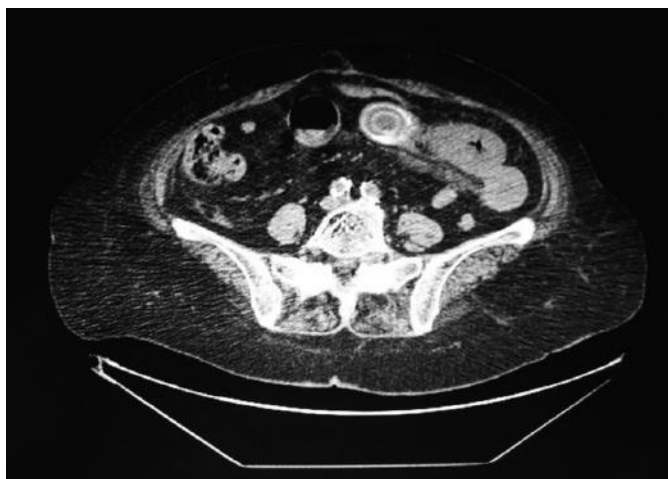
Case 2 - CT scan of the abdomen: Image showing stone in the ileum. Presence of gastric ectasia.
